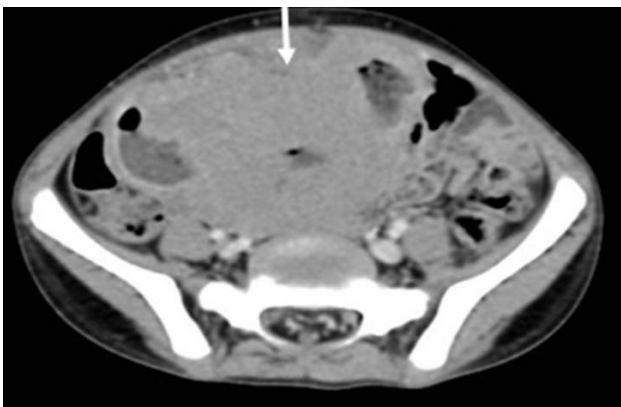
CT with contrast showing large lymphomatous mass of Burkitt extending into the pelvis
